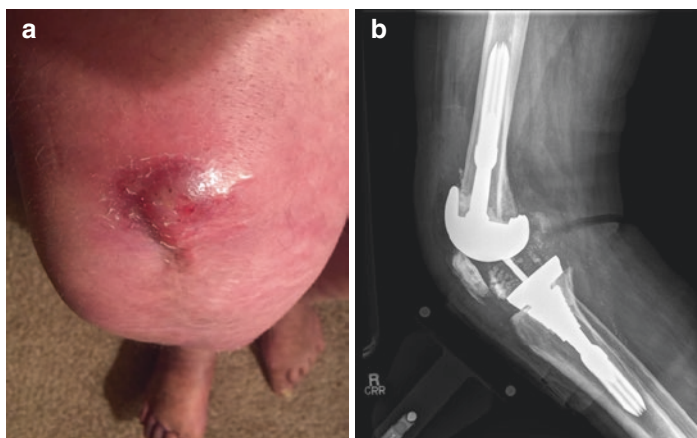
(a) Swelling and sinus tract formation over the proximal surgical incision (b) Right knee lateral radiograph
